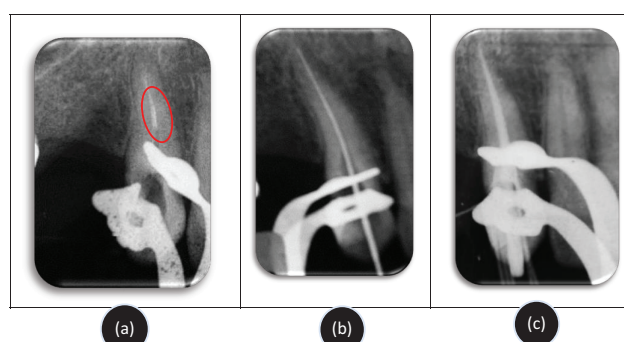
(a) Pre-operative radiograph: Separated instrument located between the middle and apical thirds of the canal; (b) Working length radiograph after removal of the fragment using the braiding technique; (c) Control radiograph after root canal obturation.
